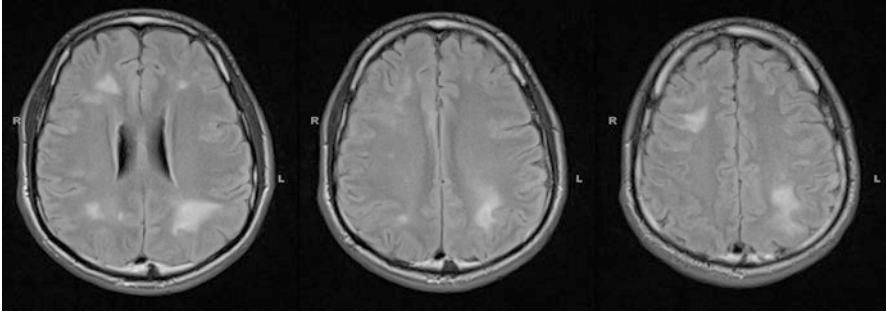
Multifocal confluent T2-FLAIR hyperintense white matter lesions including the subcortical U fibers consistent with progressive multifocal leukoencephalopathy (PML) (Images are the property of Dr. Haris Sair and the Johns Hopkins school of medicine neuroradiology teaching file)
